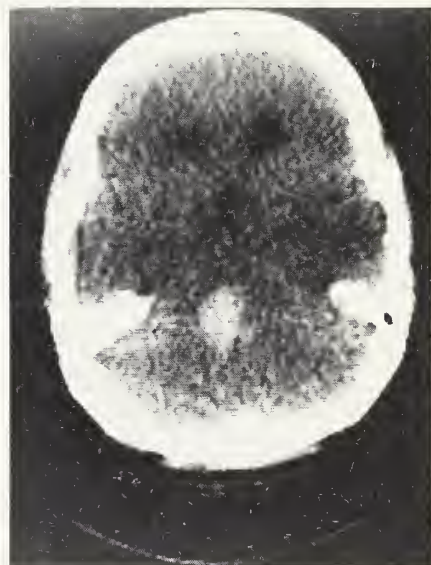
Unenhanced CT of Case 1 showing blood density in the region of the pons; other views, not shown, showed no extension of blood into the fourth ventricle.
